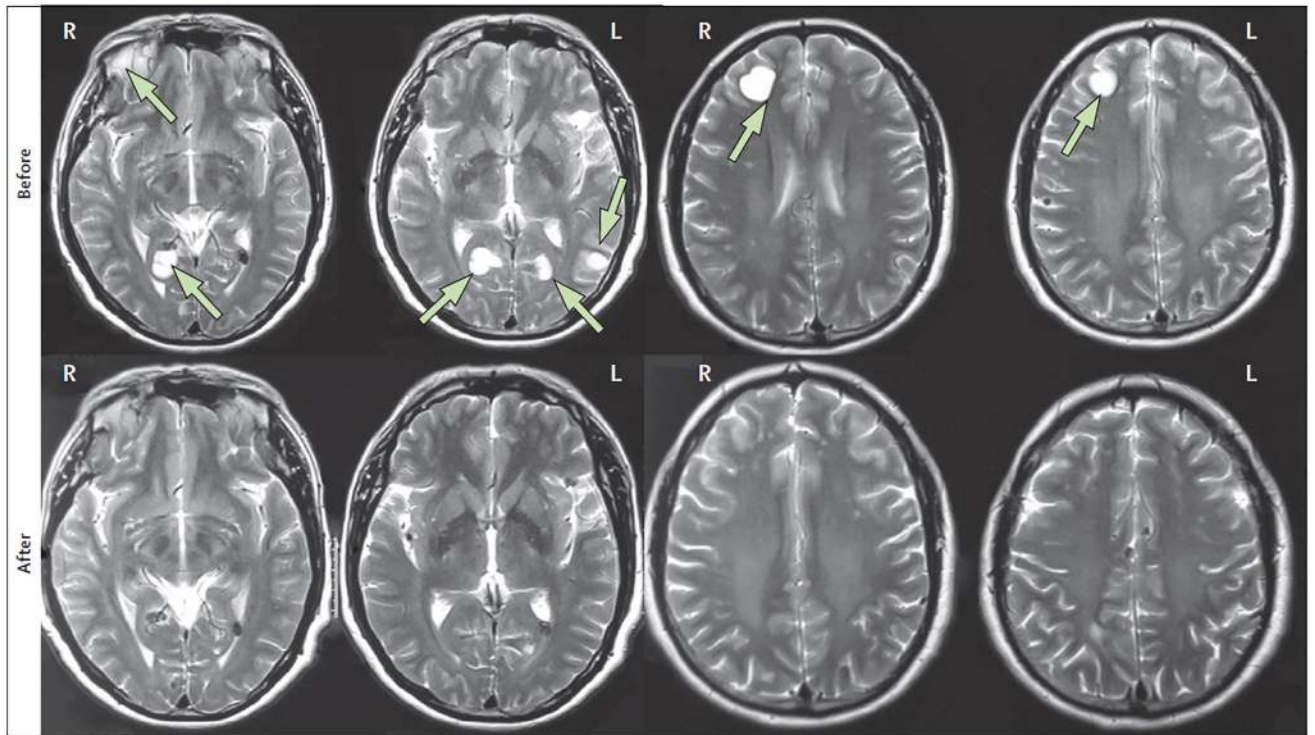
MRI scans before and after treatment in a patient with multicystic parenchymal neurocysticercosis
